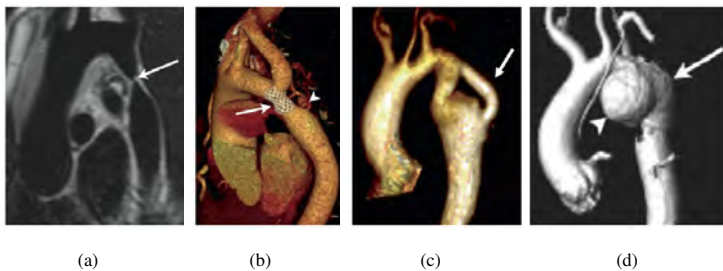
(a) 'Black-blood' MRI oblique sagittal view showing discrete, tight coarctation at the aortic isthmus (arrow). (b) 3D, contrast-enhanced CT angiogram showing mildly narrowed bare metal stent (arrow) that partially overlies the left subclavian artery origin. The arrowhead shows a subtle pseudo-aneurysm at the distal end of the stent. (c) 3D, contrast-enhanced MR angiogram showing aortic arch hypoplasia and coarctation with a 'jump' by-pass graft posteriorly (arrow). (d) 3D, contrast-enhanced MR angiogram showing large pseudo-aneurysm (arrowhead) after previous patch angioplasty repair. The true lumen is shown posteriorly (arrow) [163].
